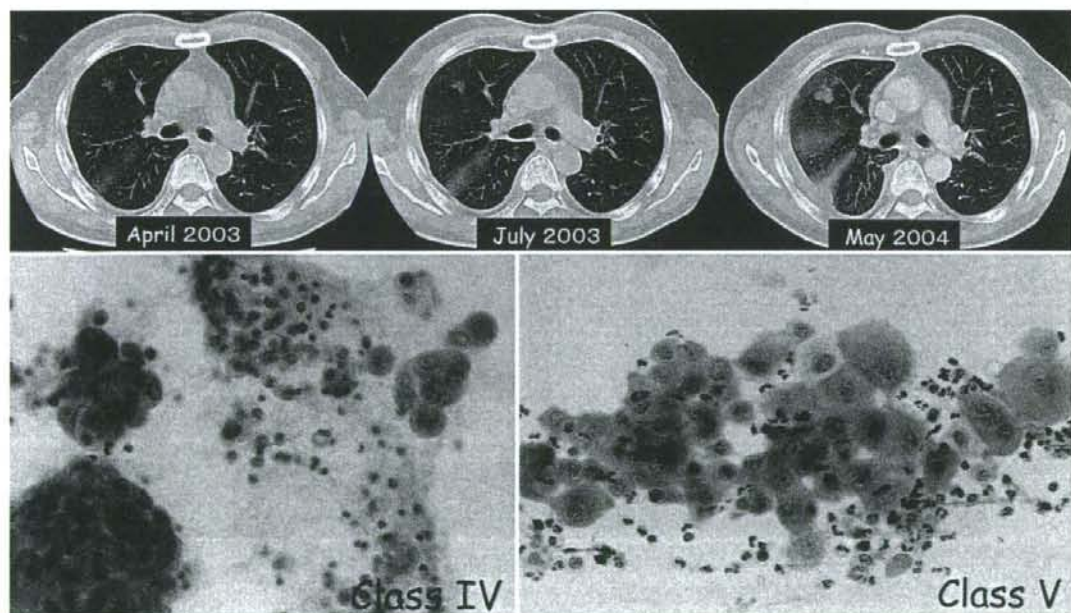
2003～2004 年の胸部 CT 画像の変化と細胞診像
